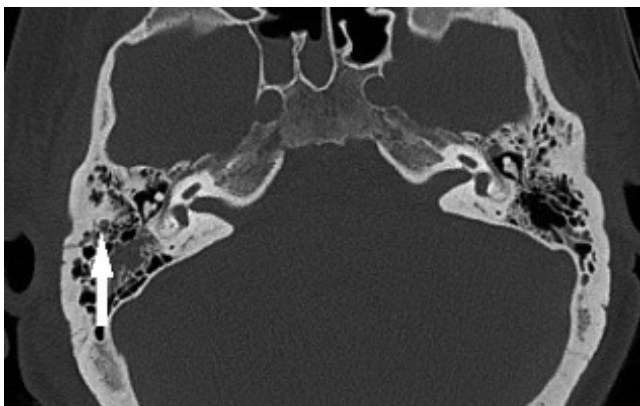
Axial CT showing right longitudinal temporal bone fracture (arrow), with incudostapedial joint disruption and widening. Note normal left incudostapedial joint.
